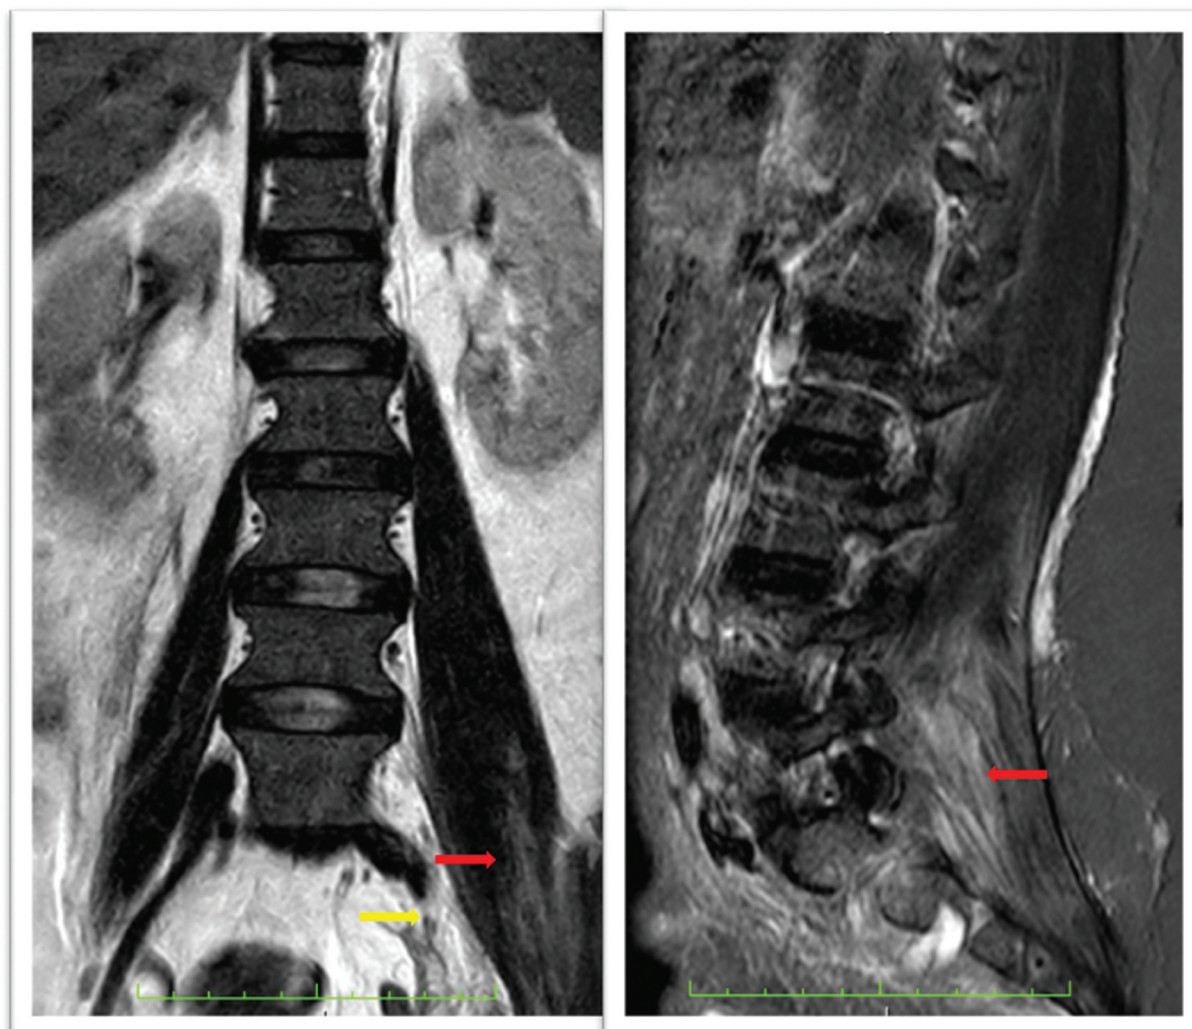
Coronal (T2) (left) and sagittal (short time investment recovery [STIR]) (right) lumbar spine magnetic resonance imaging scan, showing inflammatory changes in the soft tissues adjacent to the sacroiliac joint (yellow arrow), up to the paravertebral musculature of L3 and lamellar collection in the left iliac muscle (red arrows).
